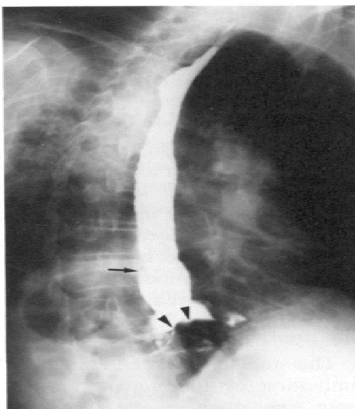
RAO single-contrast esophagus radiograph showing tear in esophageal lumen (*arrow*) and lesion partially obstructing esophagus (*arrowheads*).
